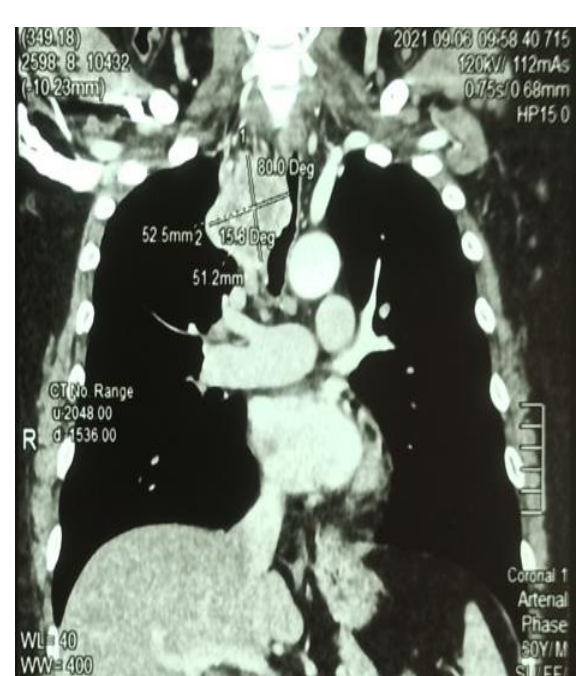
Chest CT scan on admission
